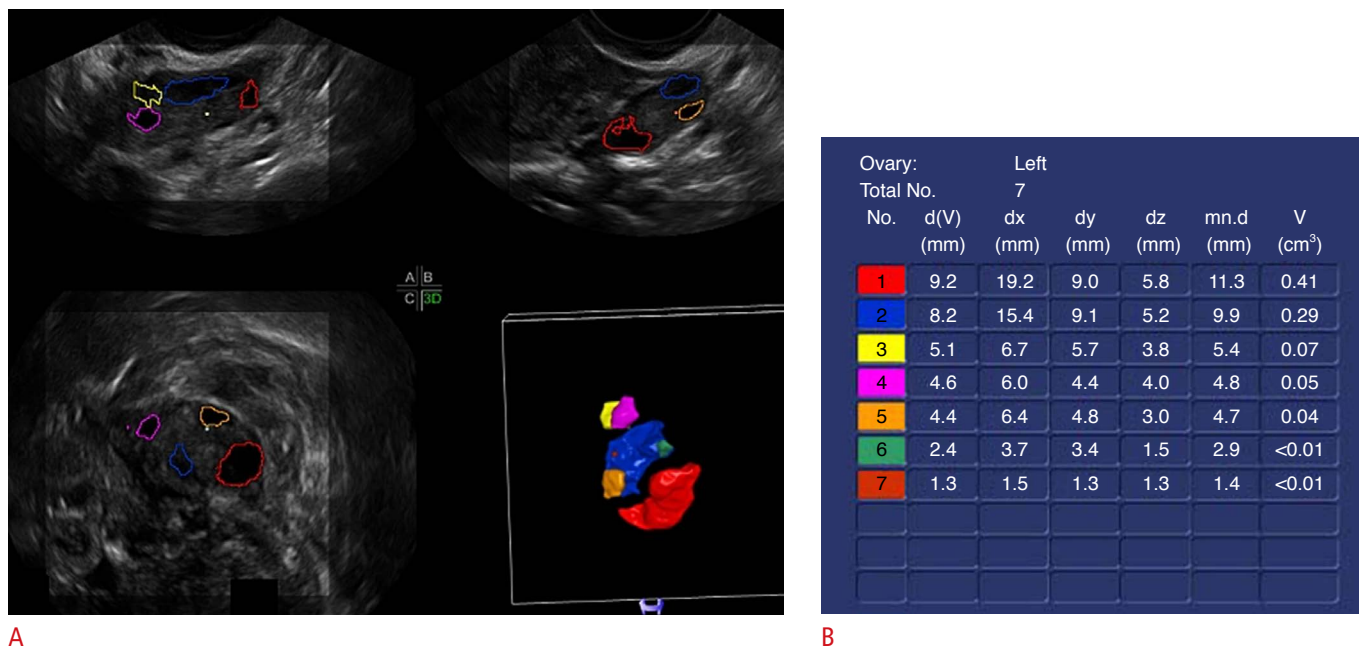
Three-dimensional (3D) sonogram of the left ovary. The images show a 3D multiplanar display of the left ovary with the follicles automatically identified, separately color-coded, and rendered opaque after subtraction of the grey scale (A). The sizes of the follicles and their volumes were tabulated using automated volume calculation (B).
